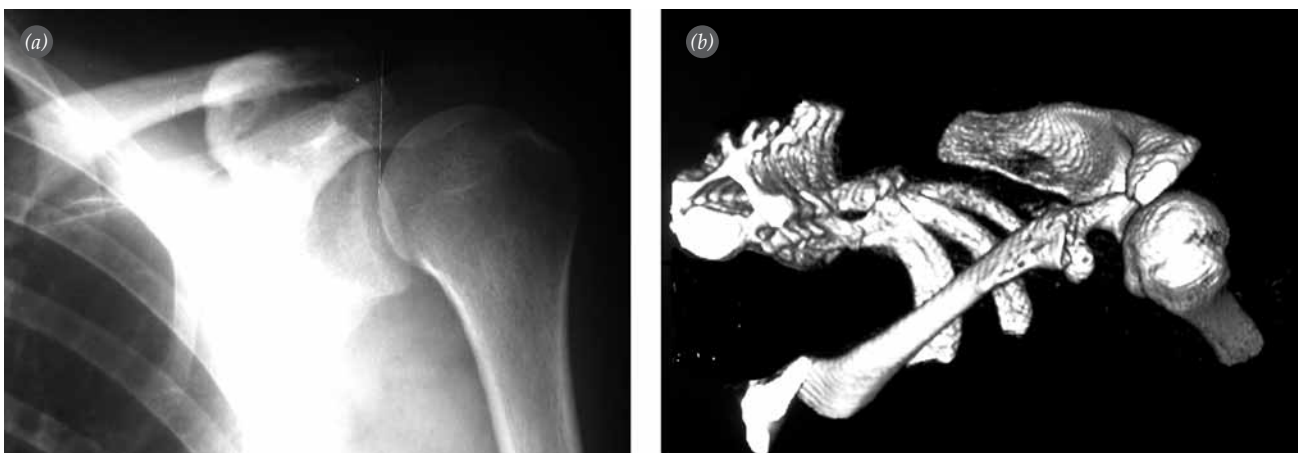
Postoperative 18th month (a) AP radiography and (b) 3D CT image.
